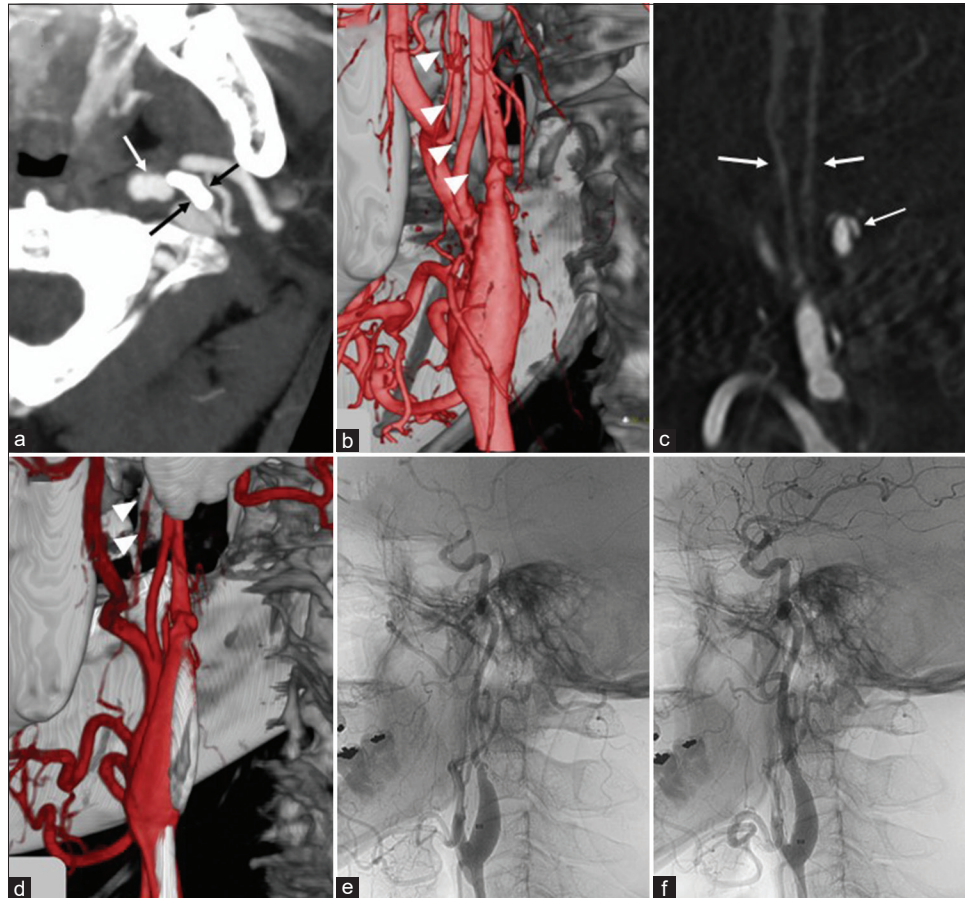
CT angiography, cone-beam computed tomography (CT), and digital subtraction angiography (DSA) of the patient. Preoperative CT angiography, axial image, demonstrating that left elongated styloid process (black paired arrows) is directly impinging on the ICA (white arrow) (a). Preoperative fusion image (cone-beam CT and 3D-DSA) demonstrating the tapered and irregular stenosis of the left internal carotid artery (ICA). The tip of elongated styloid process was very close to the ICA (arrowheads), and the ICA showed severe luminal stenosis (b). Preoperative 3D-DSA (CT-like images), sagittal view, demonstrating the false lumen (white arrow) associated with the elongated styloid process (white paired arrows) (c). Fusion image (cone-beam CT and 3D-DSA) obtained after the resection of elongated styloid process demonstrated the shortening of the styloid process (arrowhead), and the tip was no longer close to the ICA (d). The ICA angiogram (lateral view) before (e) and after (f) the procedure of carotid artery stenting (CAS) demonstrated the resolution of the left ICA stenosis.
